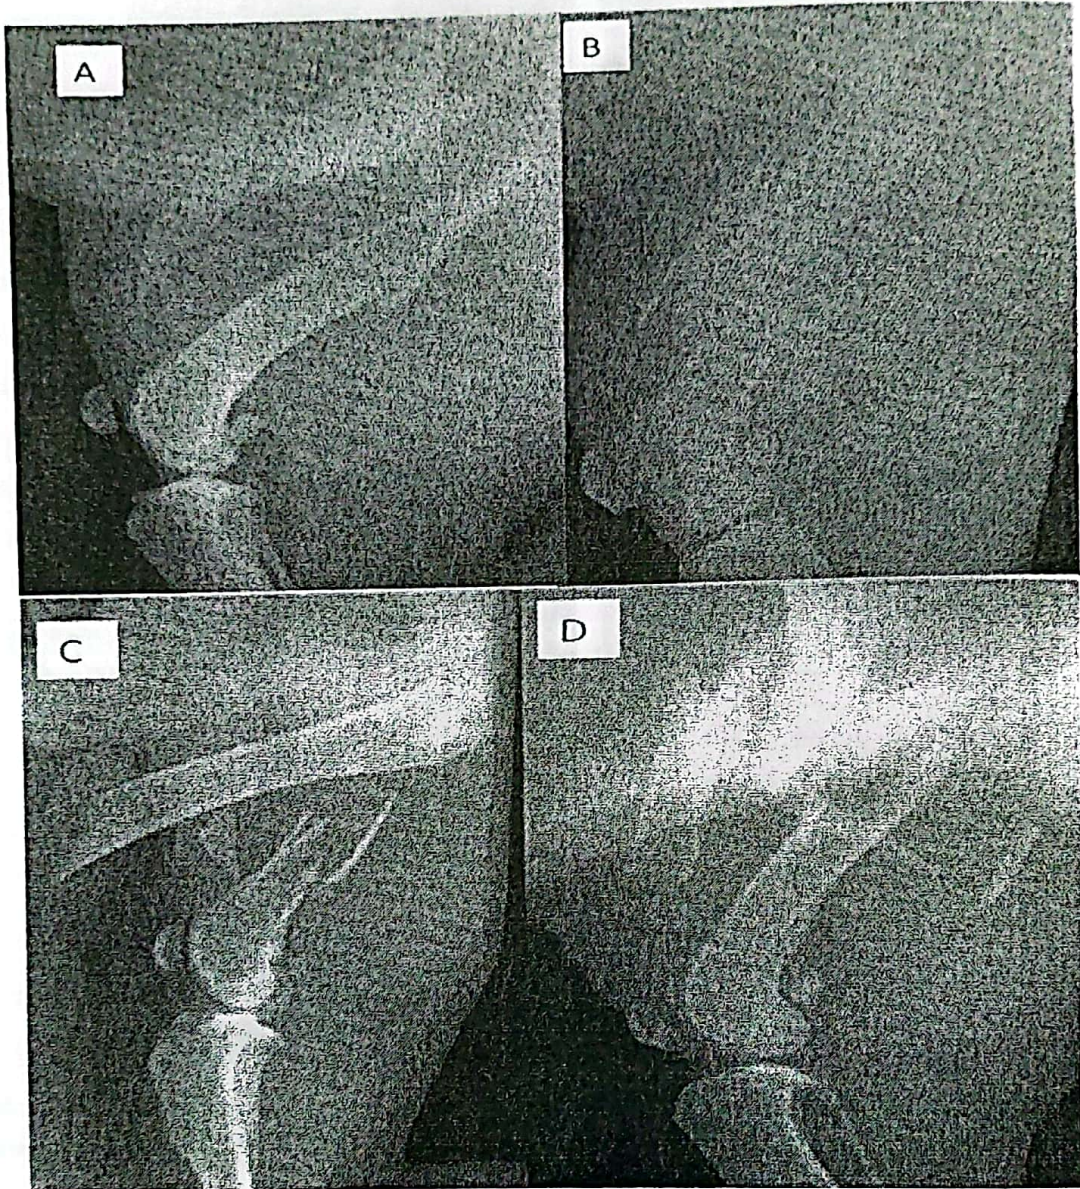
Later medial radiographs showing different varieties of comminuted femoral fractures.
